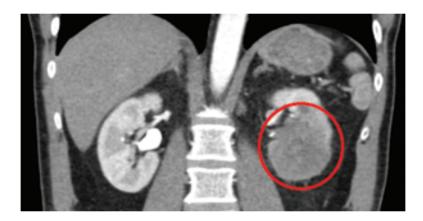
Computed tomography urogram showing new left-renal lesion in 2016.
